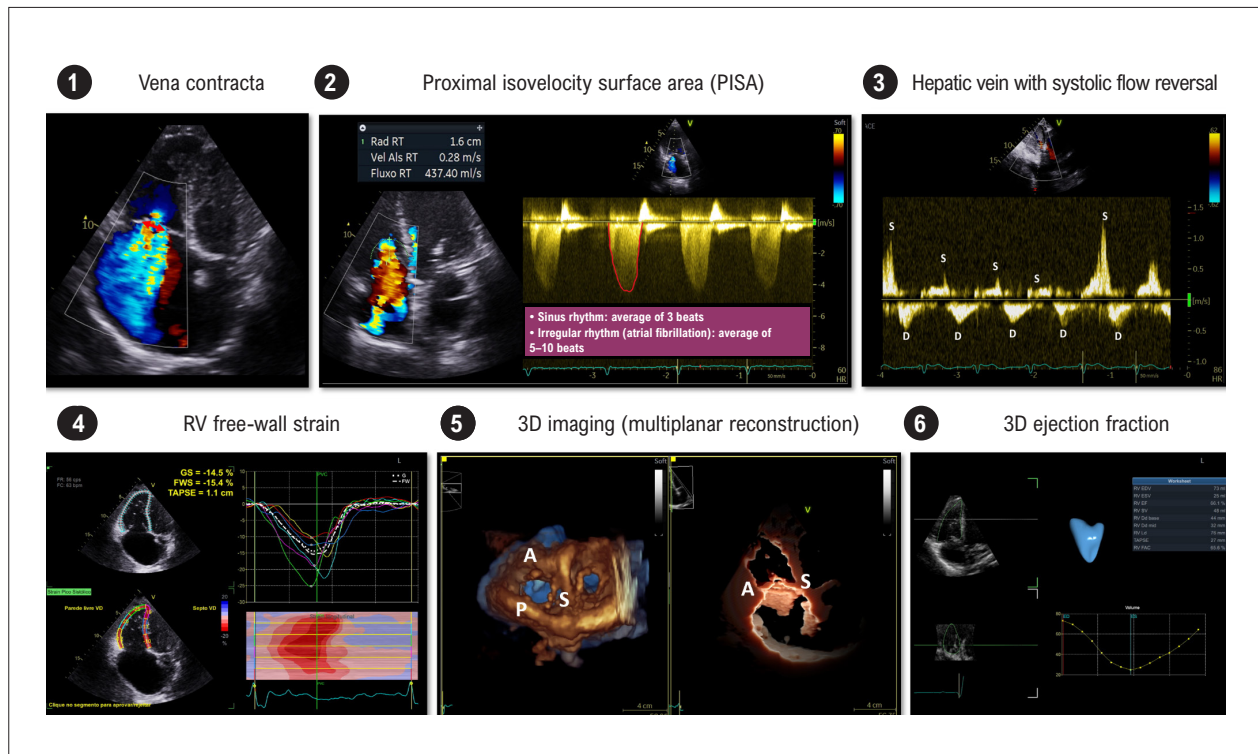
Fundamental two-dimensional and three-dimensional echocardiographic images for anatomical assessment, quantification, and prognostic analysis in patients with significant tricuspid regurgitation; “S”: septal leaflet; “A”: anterior leaflet; “P”: posterior leaflet; “RV”: right ventricle
